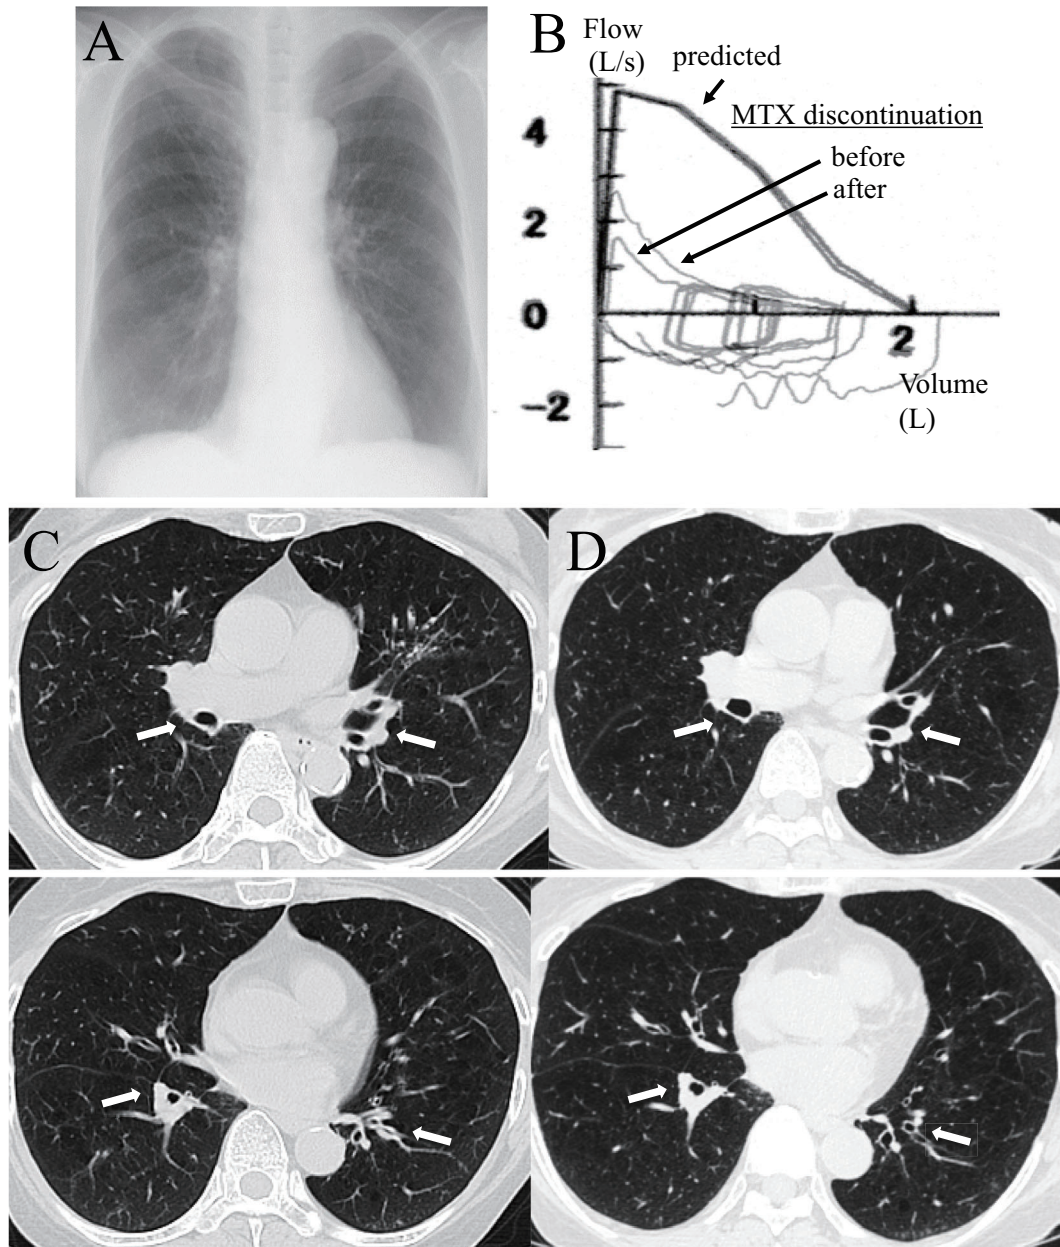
A: Chest X-ray taken three months after the discontinuation of MTX shows improvement of the nodular lesion and bilateral hilar lymphadenopathy. B: Flow-volume curves on admission and at five months after the discontinuation of MTX. C: HRCT findings before the withdrawal of MTX. The bronchial wall is thickened (arrow). D: HRCT shows that the bronchial wall thickening was reduced by four months after the discontinuation of MTX (arrow).
